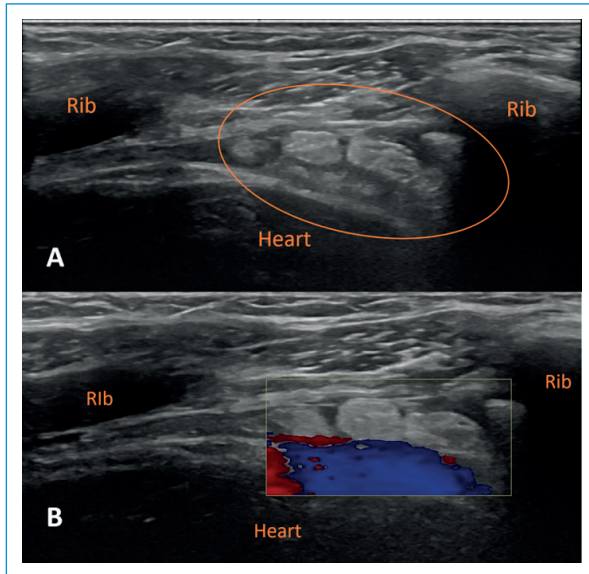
B-mode ultrasound. A: shows an area of intrathoracic fat with increased echogenicity and edema adjacent to the left cardiac border (orange circle), moving synchronously with cardiac beats, and measuring approximately 25 x 10 mm. B: Color-Doppler ultrasound does not demonstrate lesion vascularization, depicting only adjacent cardiac blood flow.
